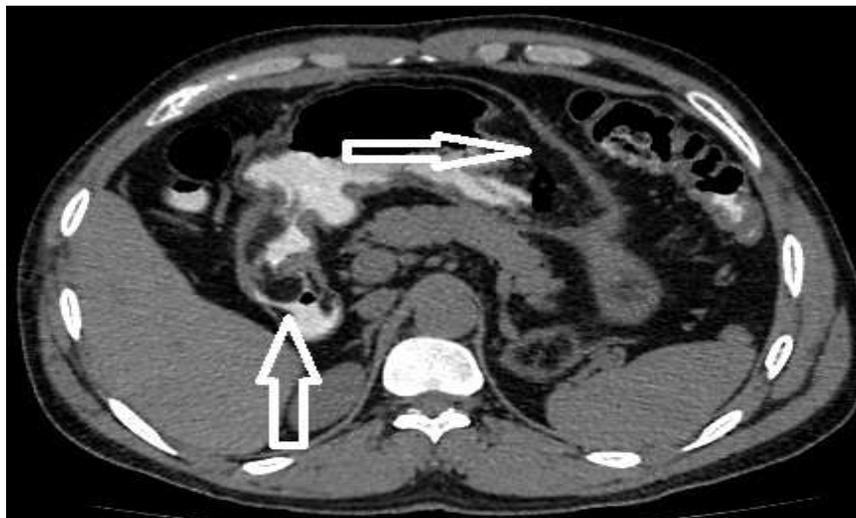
Axial post contrast CT reveals multiple lipomas in stomach one being extending in pylorus (arrows)
